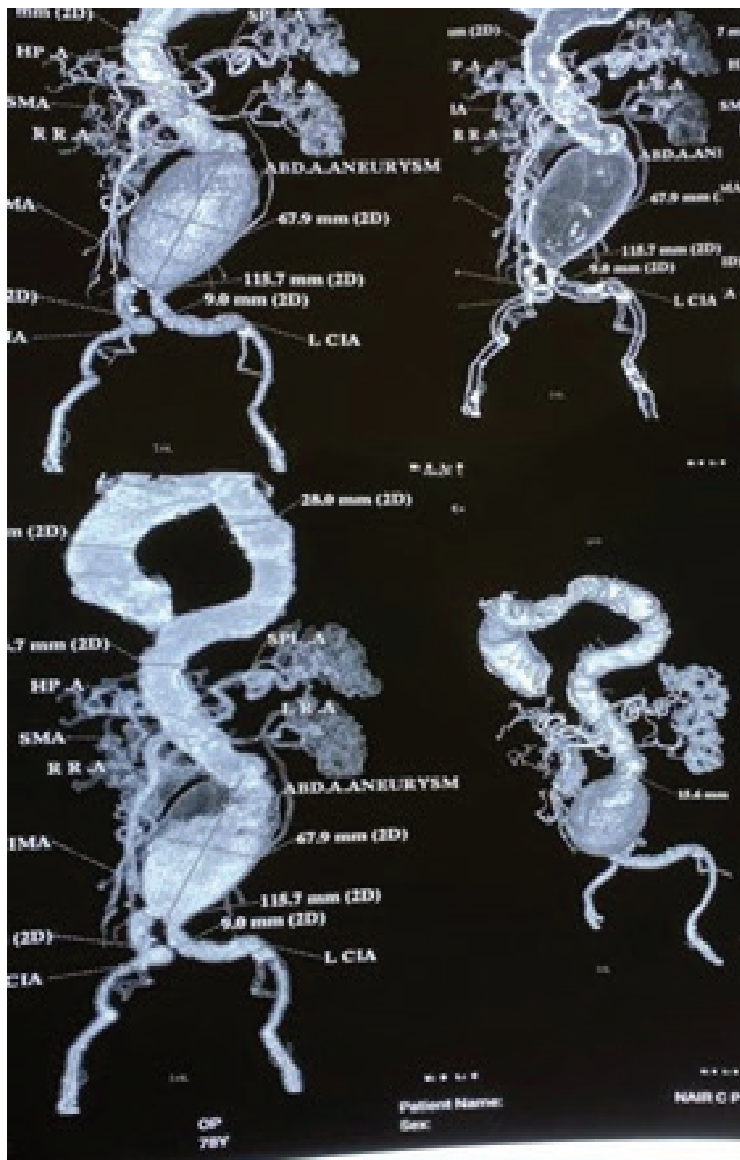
CT Aortogram showing the extent of AAA.
